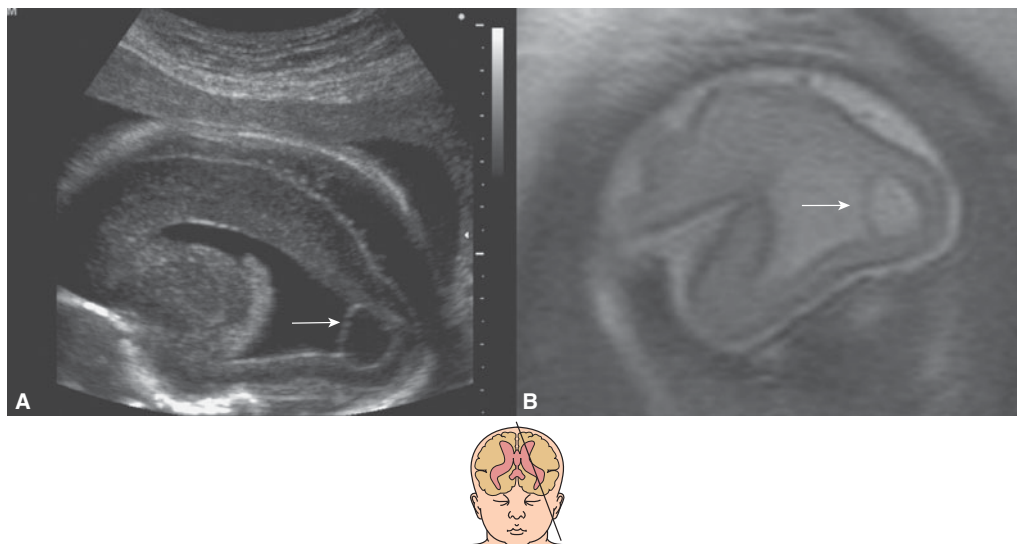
Sagittal transvaginal US (A) and MRI (B) at 24 postmenstrual weeks in a fetus with CMV. Note the similarity between the images showing the presence of a large occipital porencephalic cyst (arrows) and mild ventriculomegaly.
